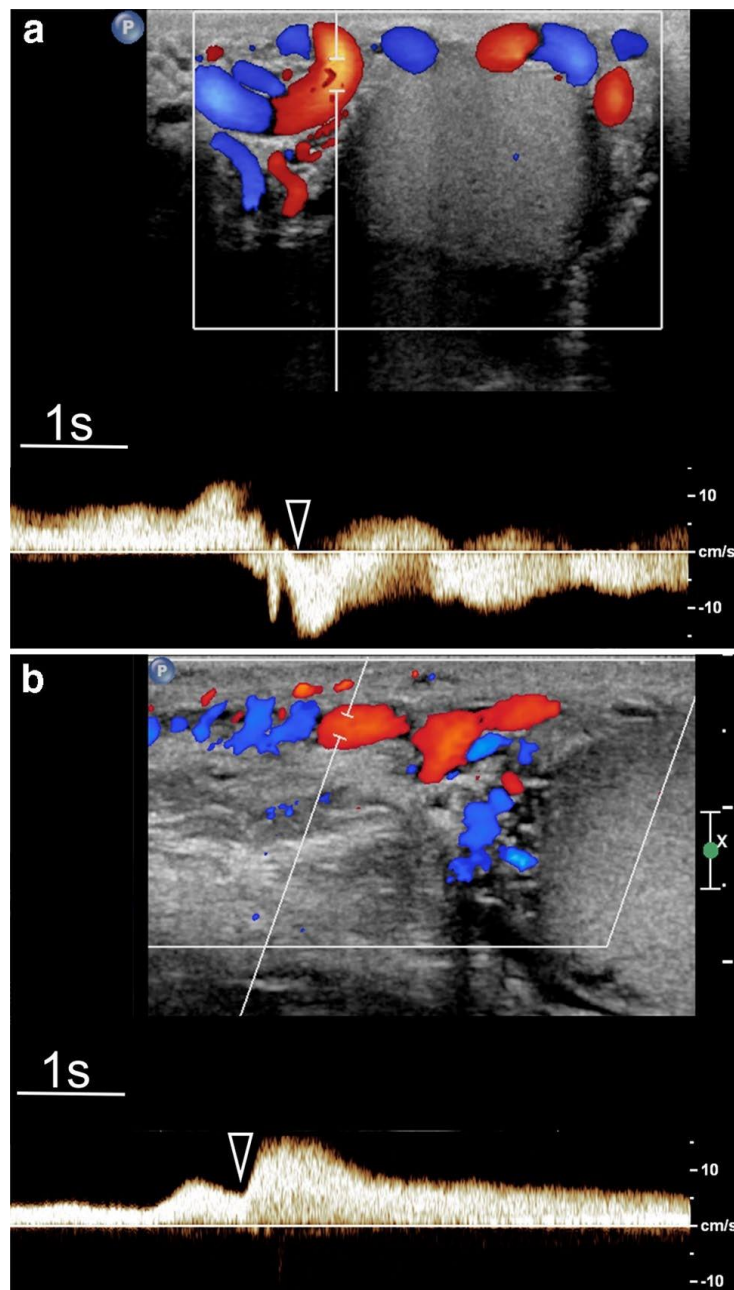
Spectral Doppler analysis in varicocele. Changes of reflux while standing during Valsalva (arrowhead). a Flow inversion. b Flow increase showing a plateau throughout Valsalva. In both cases reflux persists for more than 2 second.
